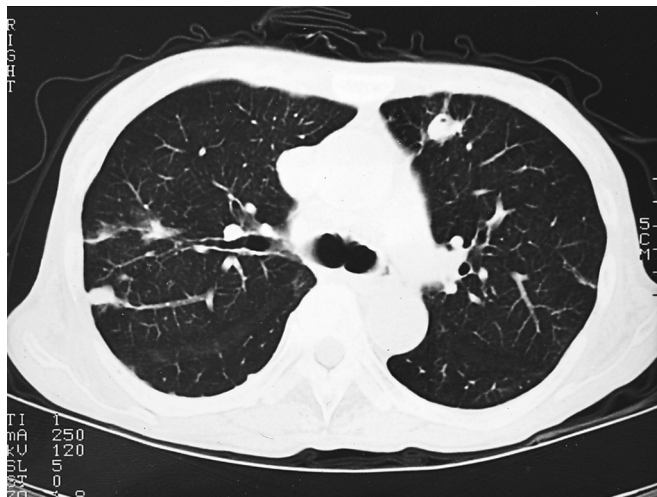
Computed tomography (CT) shows nodular shadows partly with cavitic changes, bronchiectasia, and calcifications in both lung fields in December 1994
